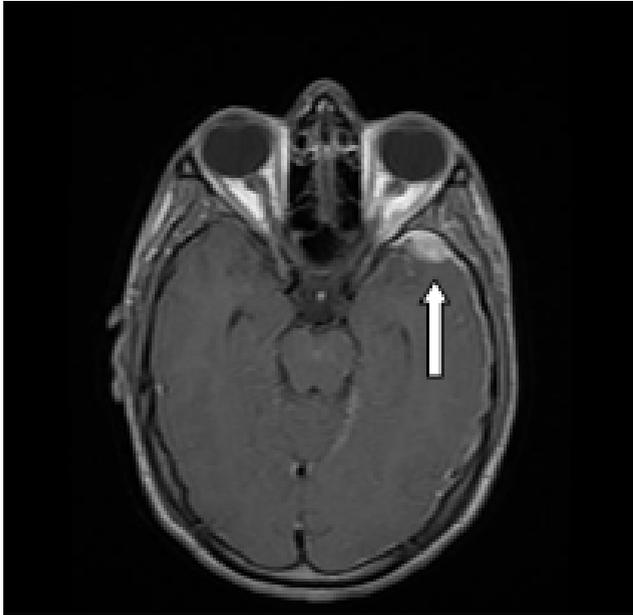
T1 Magnetic Resonance Imaging Showing Meningioma
